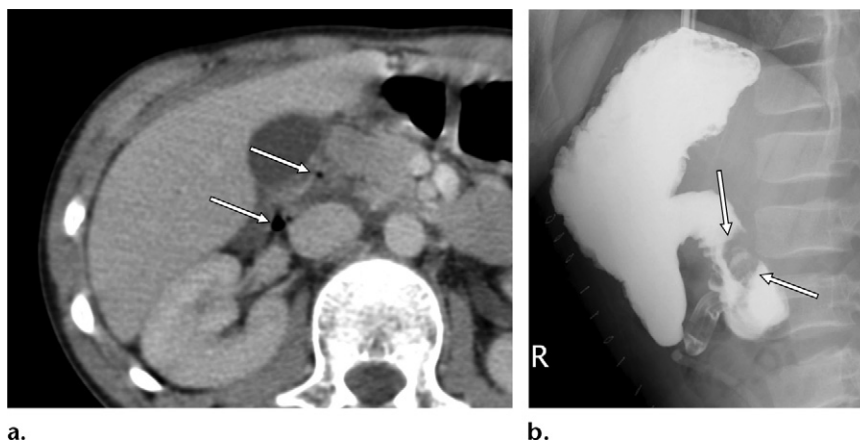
Free air in 14-year-old male adolescent who presented with upper abdominal pain after sustaining blunt abdominal trauma from the handlebars of his bicycle. (a) Axial contrast-enhanced CT image shows a small amount of extraluminal fluid and free retroperitoneal air (arrows) adjacent to the duodenum, a finding that was suggestive of a duodenal perforation. At laparotomy, this finding was confirmed, and the perforation was repaired. Because of the patient's persistent upper abdominal discomfort, a barium study was performed 6 days later. (b) Radiograph from the barium study shows a duodenal filling defect (arrows), which is consistent with a duodenal hematoma.
